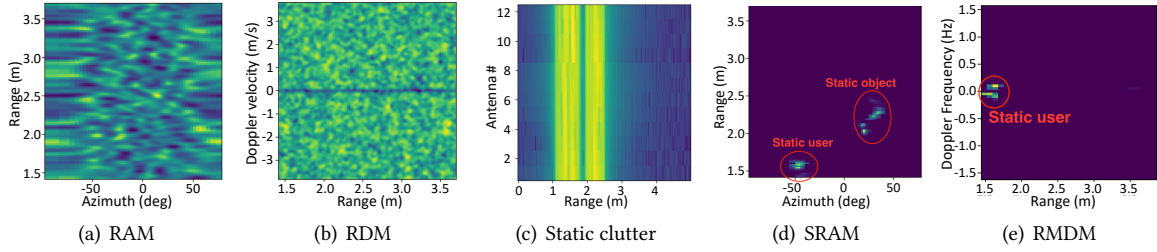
Detecting static users under still scenes. (a–b) show the raw range–azimuth map (RAM) and range–Doppler map (RAM), while (c) visualizes the strong near-zero Doppler reflections constituting static clutter. Through beamforming and micro-motion analysis, static targets are effectively separated into (d) the static RA map (SRAM) and (e) the range–micro-Doppler map (RMDM), enabling precise identification of static users and surrounding objects.
